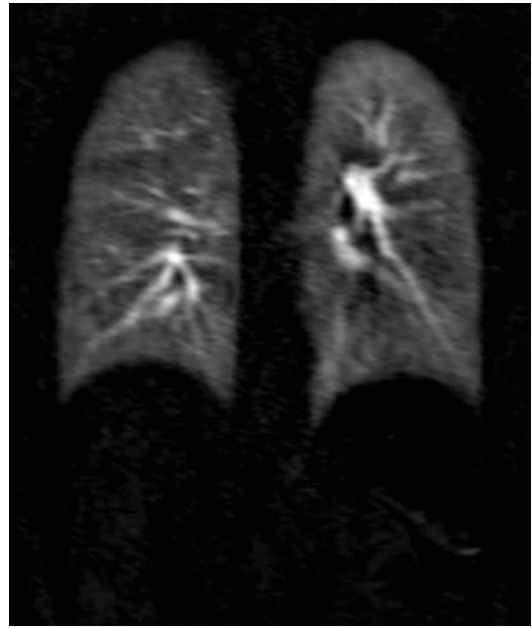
T1-weighted 4D contrast-enhanced first pass perfusion study (T1-weighted 3D-GRE with echo sharing, TWIST, subtracted image, coronal acquisition in breath-hold, healthy, 30-year-old male subject)
